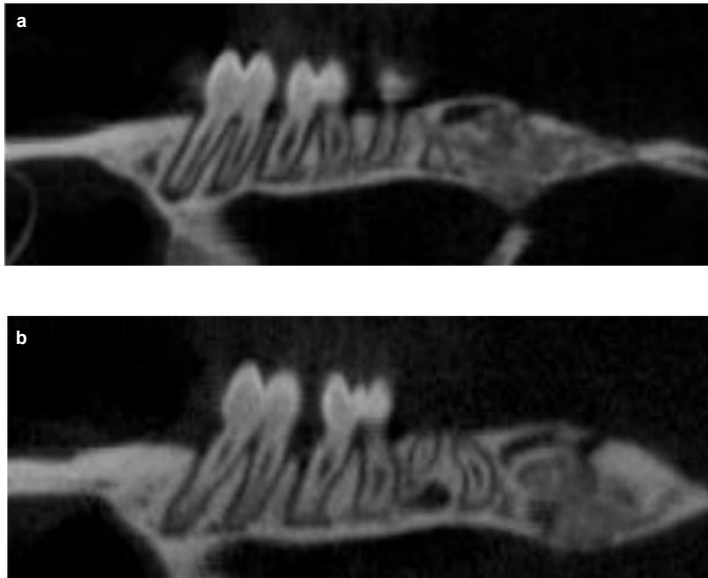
a: μ CT image of upper molars at baseline. b: μ CT image of upper molars at 14 days.
